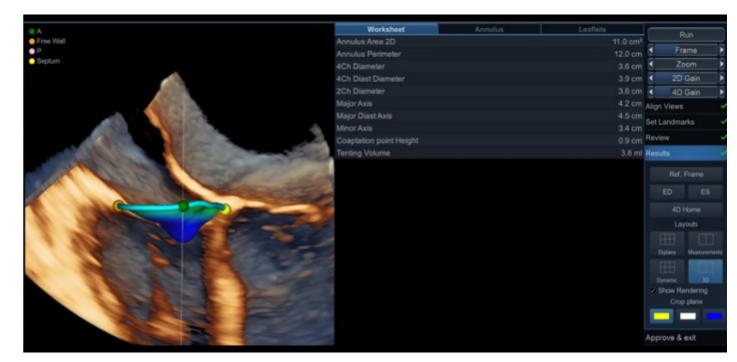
TV annulus and leaflets model superimposed on the 3D rendered 4-chamber view on transesophageal data set.
